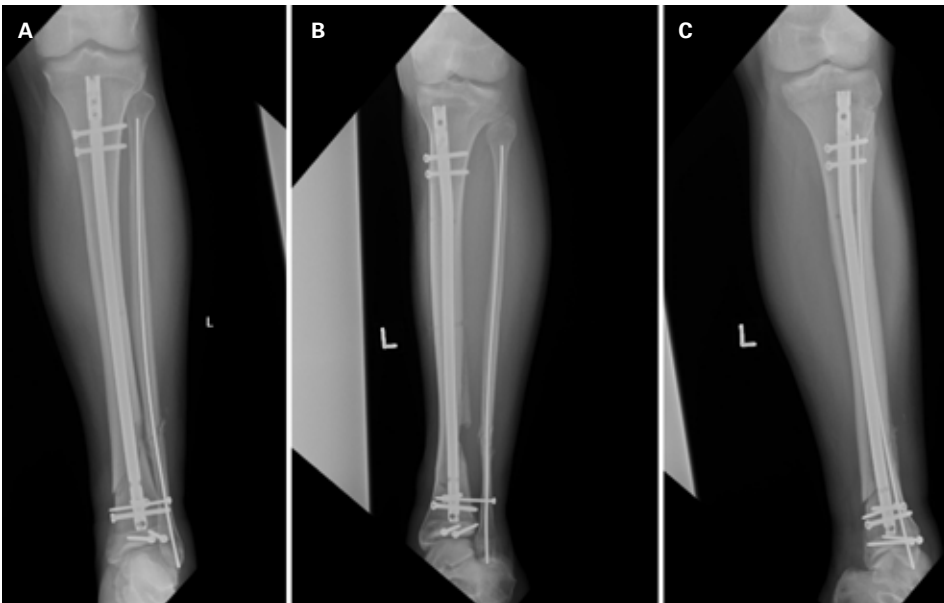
Anteroposterior, oblique, and lateral radiographs of the left tibia and fibula 8 weeks postoperatively demonstrating interval healing at the distal tibia and fibula fracture sites with callous formation.
